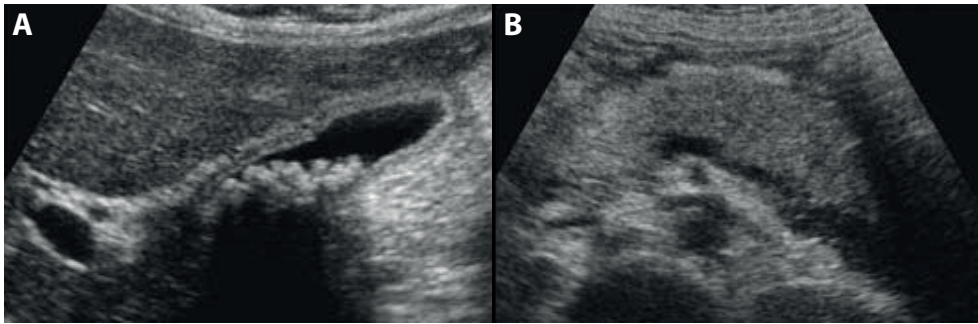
Ultrasound of cholelithiasis and biliary pancreatitis. (A) Ultrasound depicts multiple tiny stones in a non-distended gallbladder as cause of biliary pancreatitis. (B) Ultrasound showing a slightly swollen pancreas with surrounding hypoechoic fluid.
